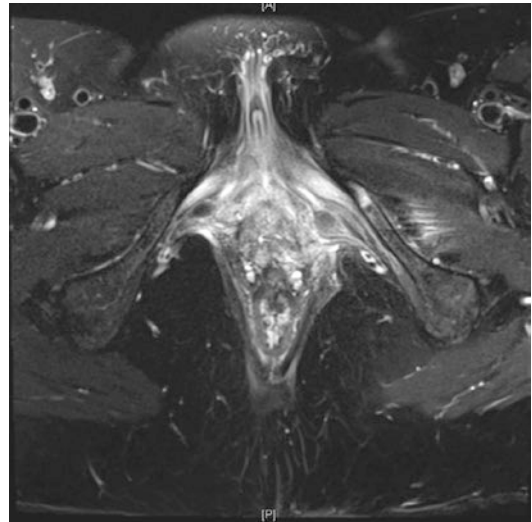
Axial T2-weighted MR image of enhancing periurethral mass with extensive encasement of the urethra suspicious for urethral carcinoma
